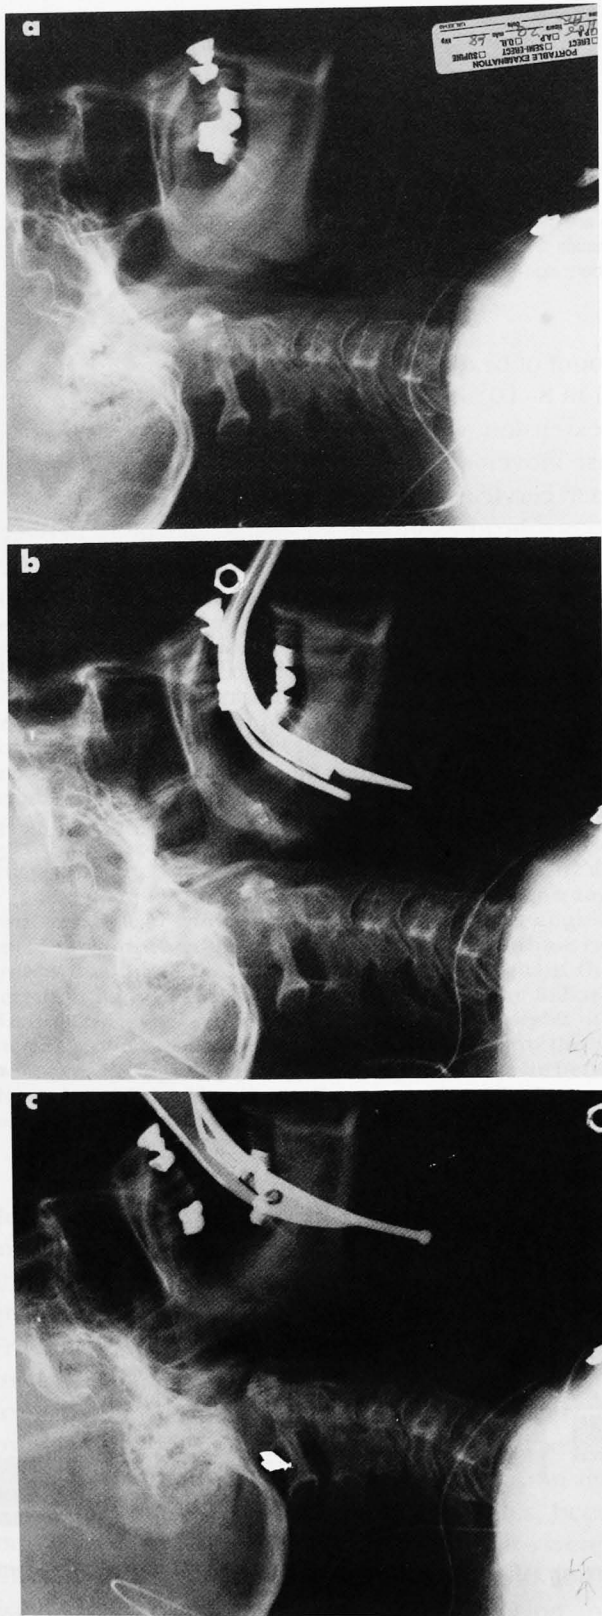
Lateral radiographs taken in one patient showing the condition of the cervical spine at baseline (a) and during laryngoscopy with best laryngeal view with the Bullard (b) and Macintosh (c) laryngoscopes. Cervical spine angles in each film are representative of the median values from the study. Cervical spine extension is greater with the Macintosh laryngoscope. For example, the spine is much more curved in c than in a or b. In addition, the gap between the occiput and the spinous process of C1 is much smaller in c than in a or b, indicating greater extension at the atlantooccipital joint. The distance from the vertebral column to the laryngoscope blade tip is less in b than in c, showing that the Bullard blade is not lifted as much anteriorly as the Macintosh blade. The radio-opaque circle overlying the patient's skull in c is a part on the angle finder, attached to the patient's head.
